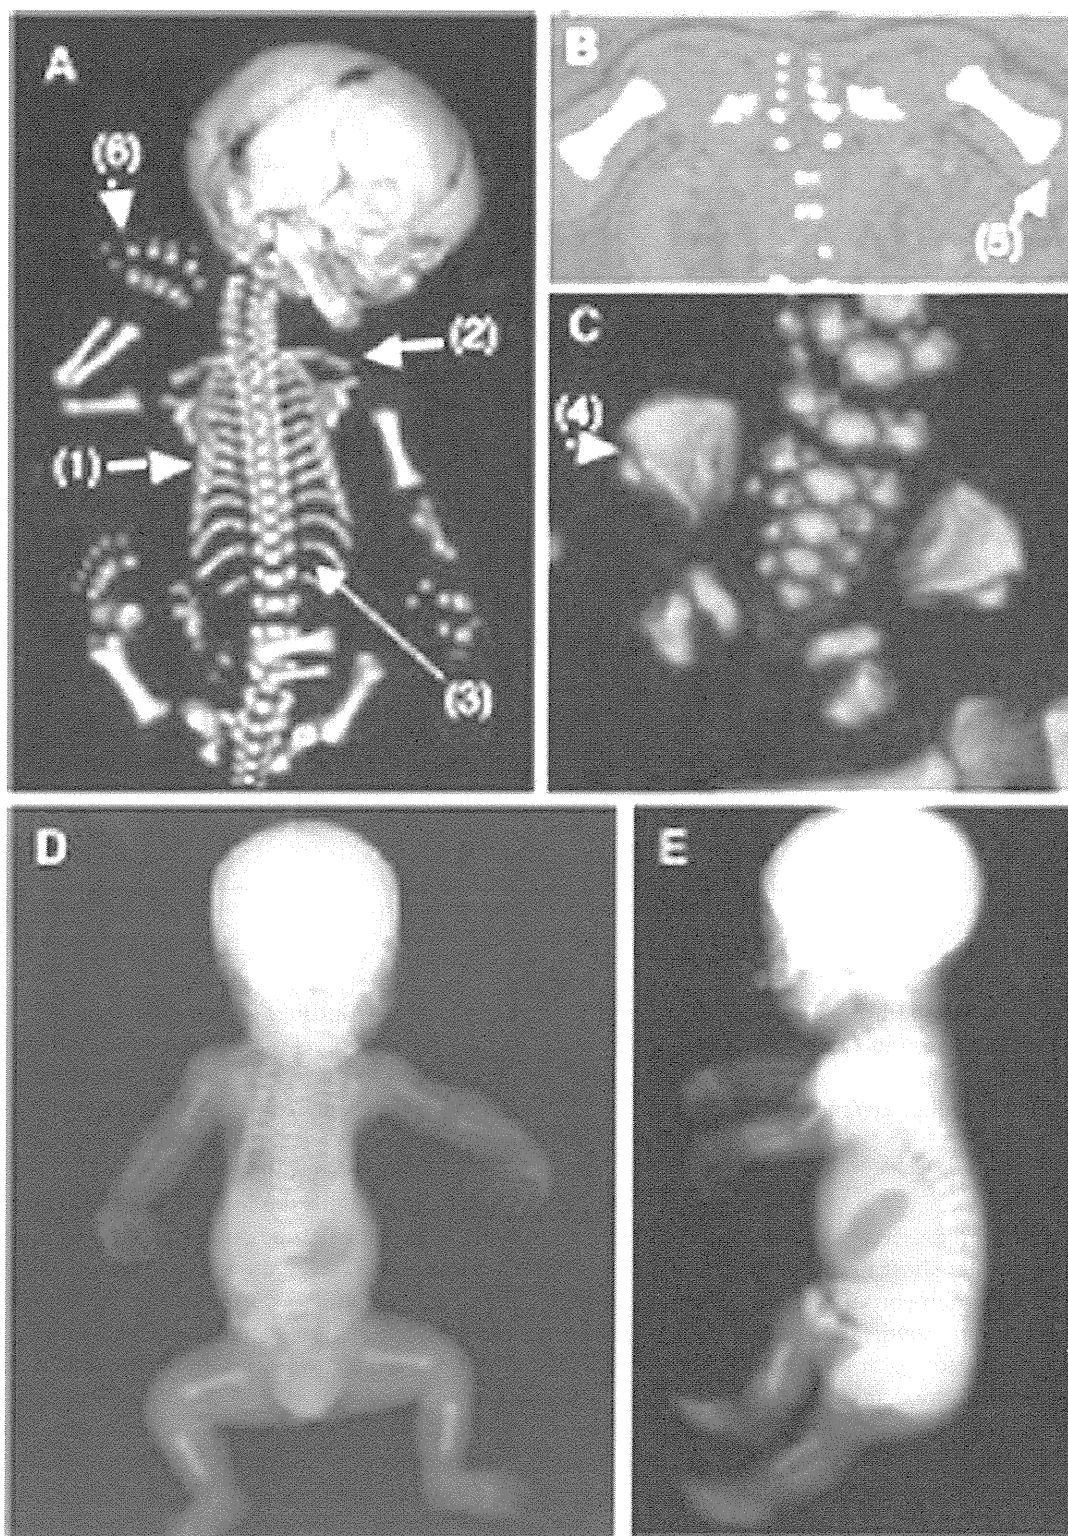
(a–c) Fetal computed tomography (CT) showed a narrow thorax (1), high-rising clavicles (2), mild modification of the vertebral bodies (3), small ilia with horizontal acetabula and triangular ossification defects at the inferior aspect of the lateral iliac margin (4), subtle metaphyseal irregularities of the femora (5), and brachydactyly with postaxial polydactyly (6). (d,e) Radiological findings on postnatal radiographs were identical to those of fetal CT.
